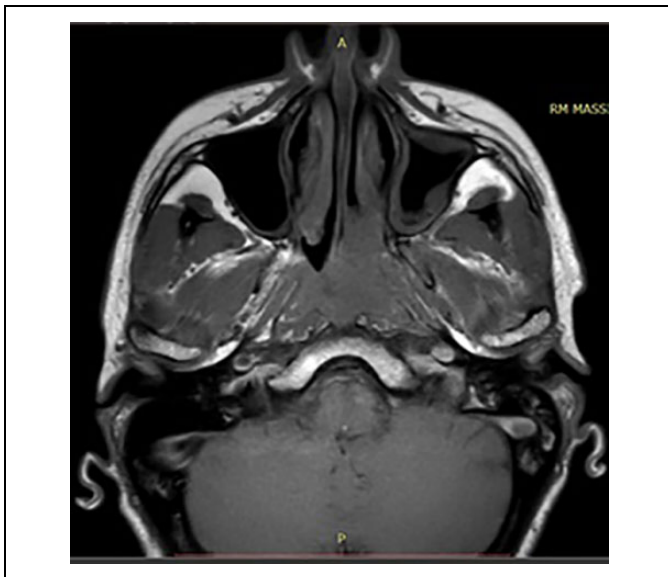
Pretreatment magnetic resonance imaging (MRI) with contrast.
